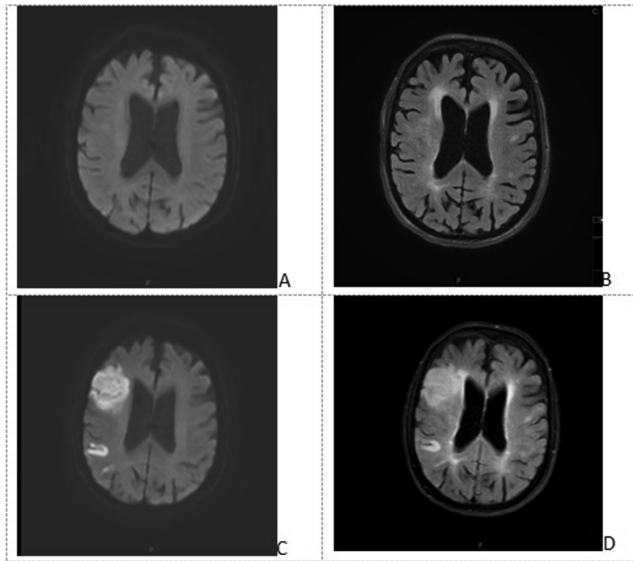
Magnetic Resonance Imaging at presentation and day 3
